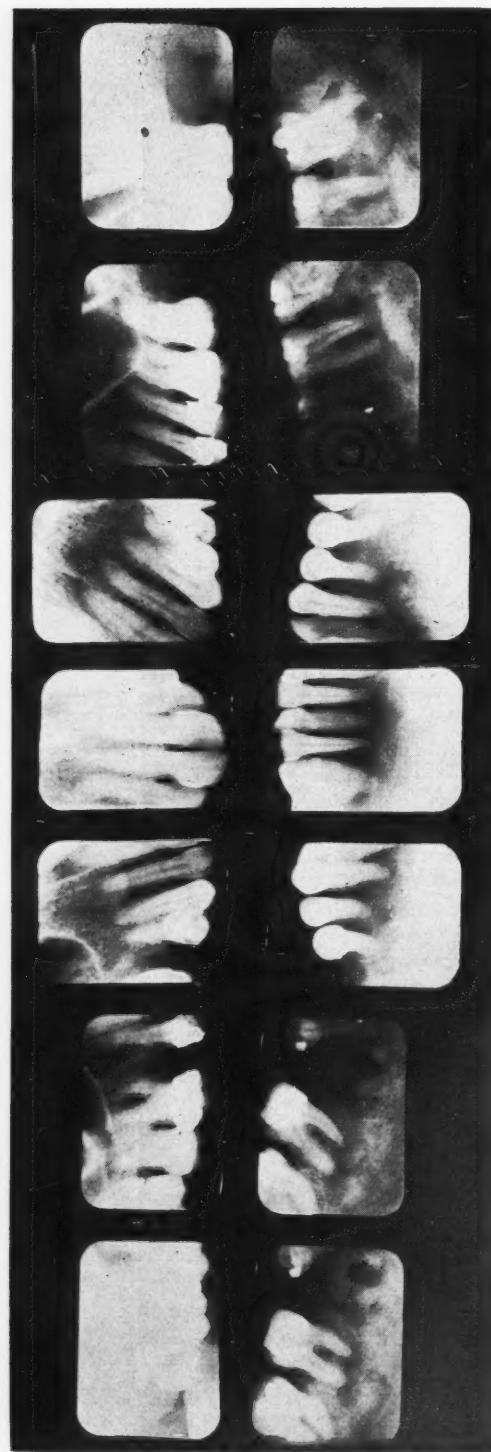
Intraoral roentgenograms showing typical pictures of primary chronic osteomyelitis of the mandible. This, however, does not appear to be an infective process. The teeth are all vital, firm and of good appearance. I have made roentgenographic check-ups in this case, and there has been no change in the last four years. The general physical examination does not aid in determining the etiology of the disease in this particular case. It is possibly due to a diet deficiency.
